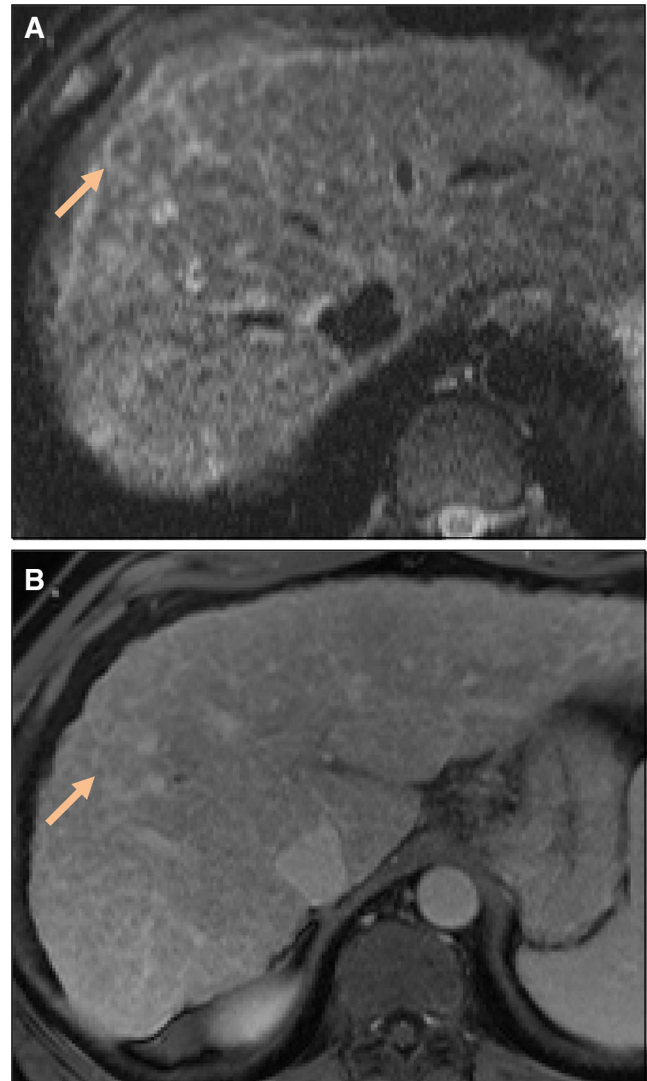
A, B Bands of linear hepatic fibrosis on MRI are (A) T2 hyperintense on T2 FS sequence and (B) show delayed enhancement.
